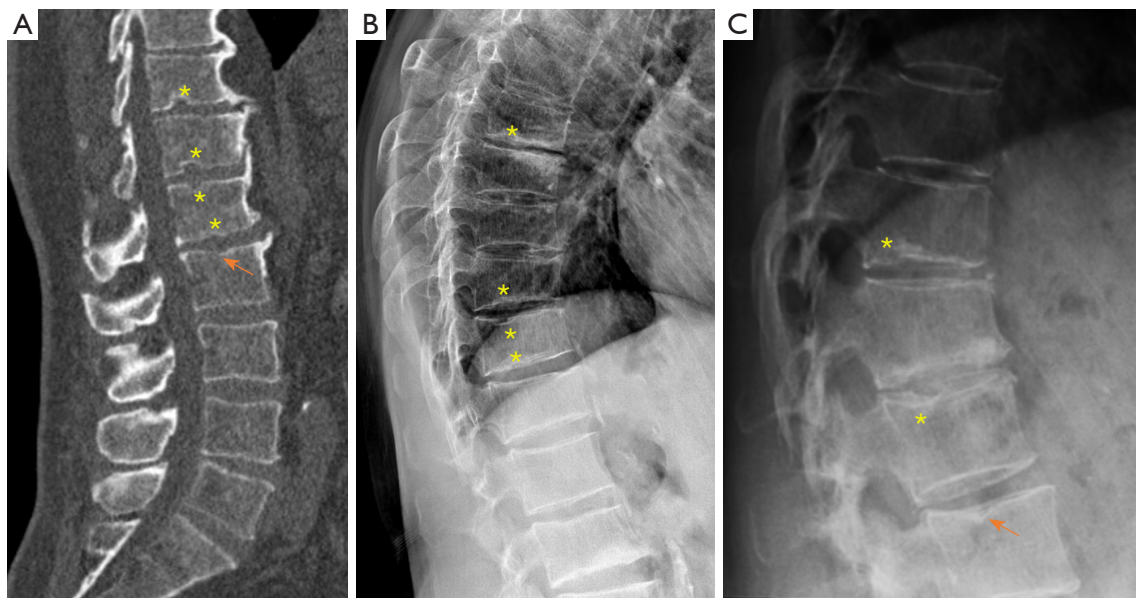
Image examples of SNd. (A) Reconstructed CT image. (B) Radiograph. Multiple acquired short vertebrae are noted. However, a few SNd might have been missed due to the projectional nature of radiograph. (C) Radiograph. * indicates SNd, arrow indicates a possible SNd. SNd, Schmorl's node of primary developmental cause; CT, computed tomography.
